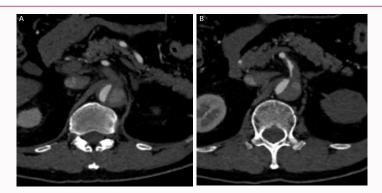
A: Initial computed tomography scan showing occlusion of the celiac artery. B: Initial computed tomography scan showing severe stenosis of the superior mesenteric artery.
